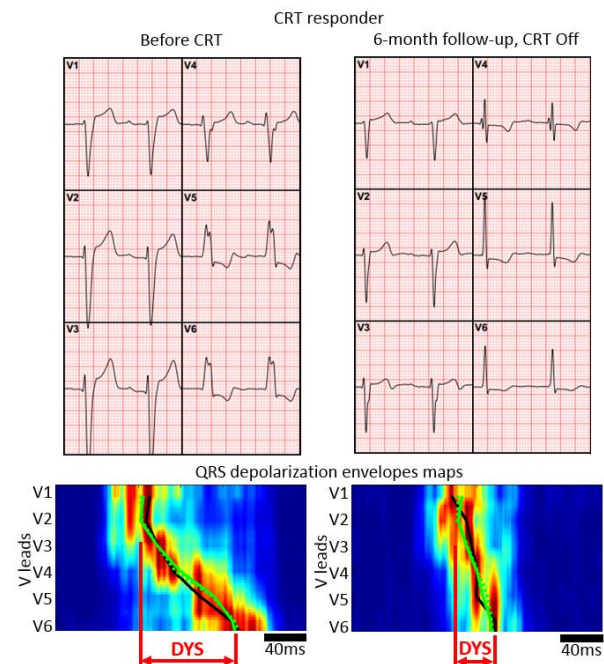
Example of the CRT responder by echocardiography (ESV increase by 12%); with extensive
